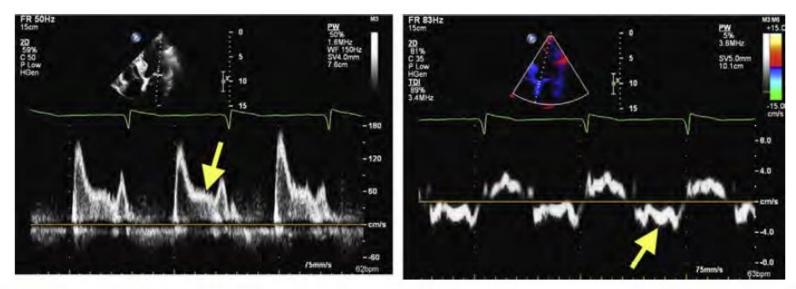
L velocity from a patient in sinus rhythm and increased LAP. Notice the presence of L velocity in mitral inflow and septal tissue Doppler signals (arrows).
